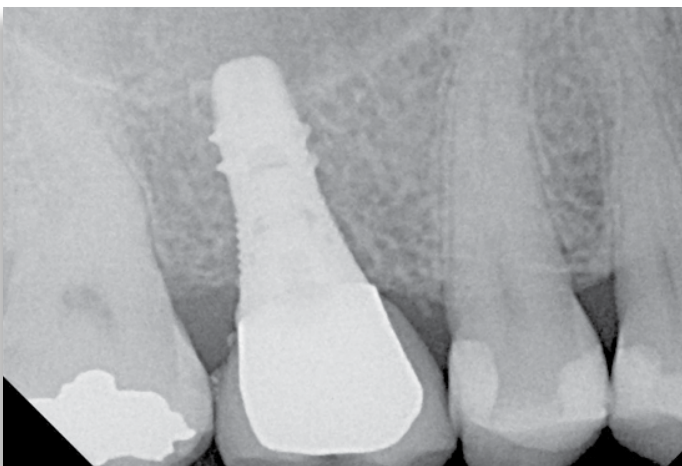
Final radiograph of implant-retained maxillary first molar cemented into place.
